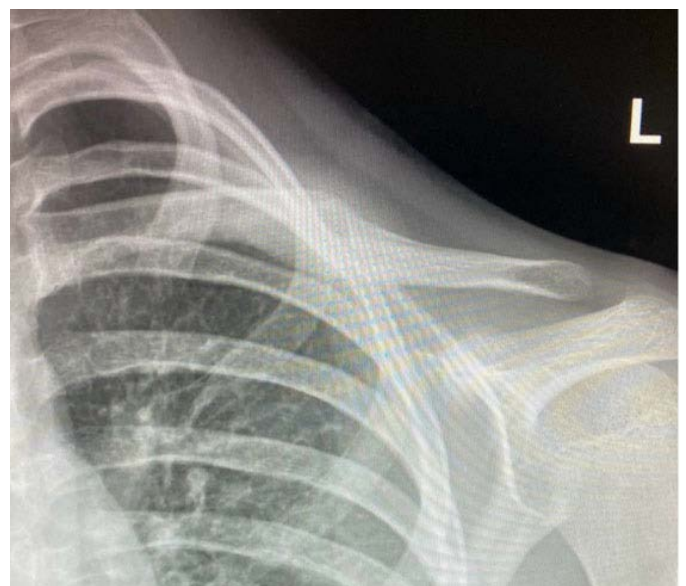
AP radiograph of the left clavicle at three months post-injury.
